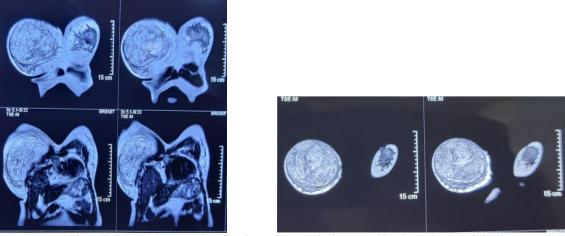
& 2; MRI images showing hyperintense lesion completely replacing right breast.
